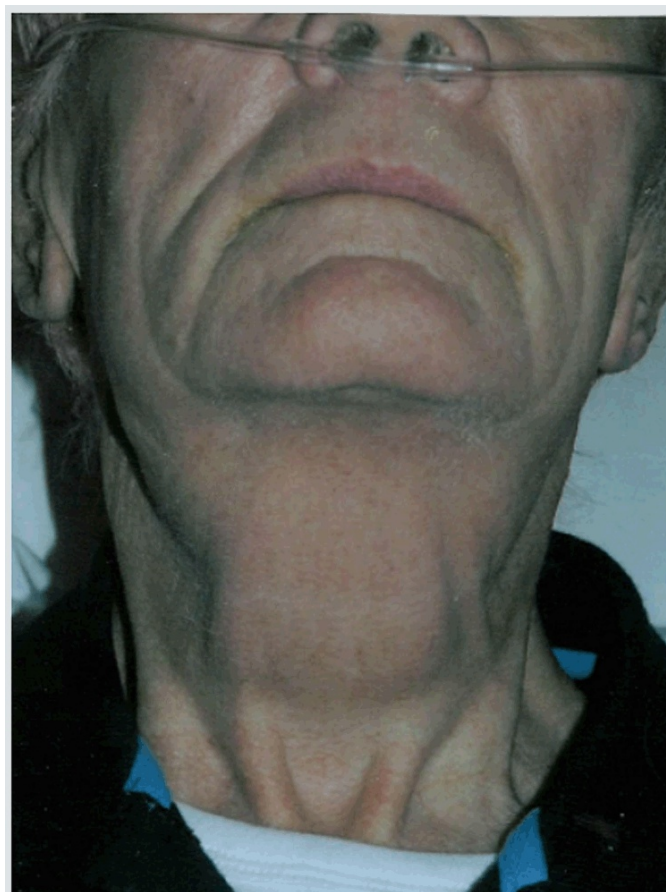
Diffuse, bilateral, symmetrical submandibular gland enlargement four hours after CT scan.
